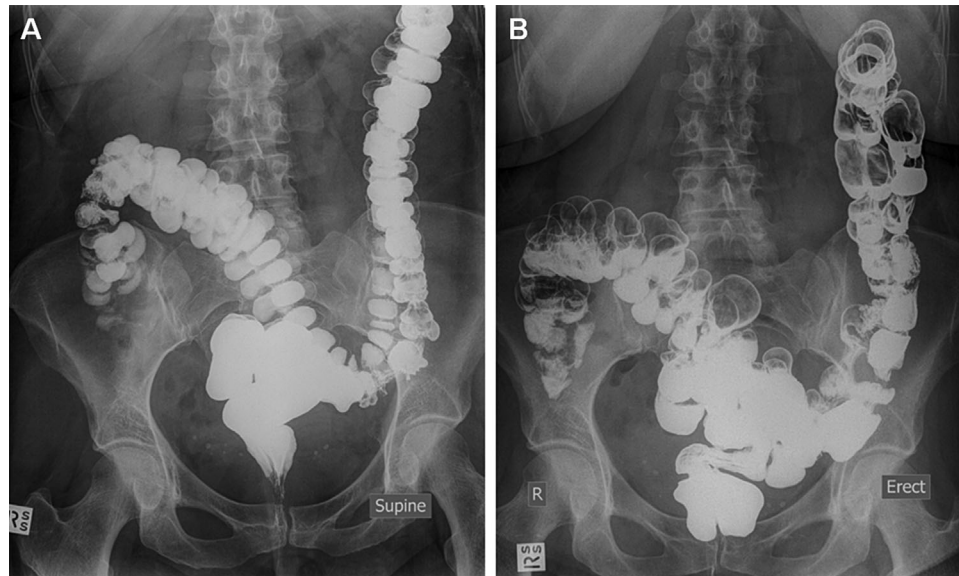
Contrast abdominal radiograph in an adult with JHS/EDS-HT. Comparison between the supine (A) and erect position (B). There is an overt downward dislocation of the entire colon, sigmoid, and rectum in orthostatism compared to clinostatism.
